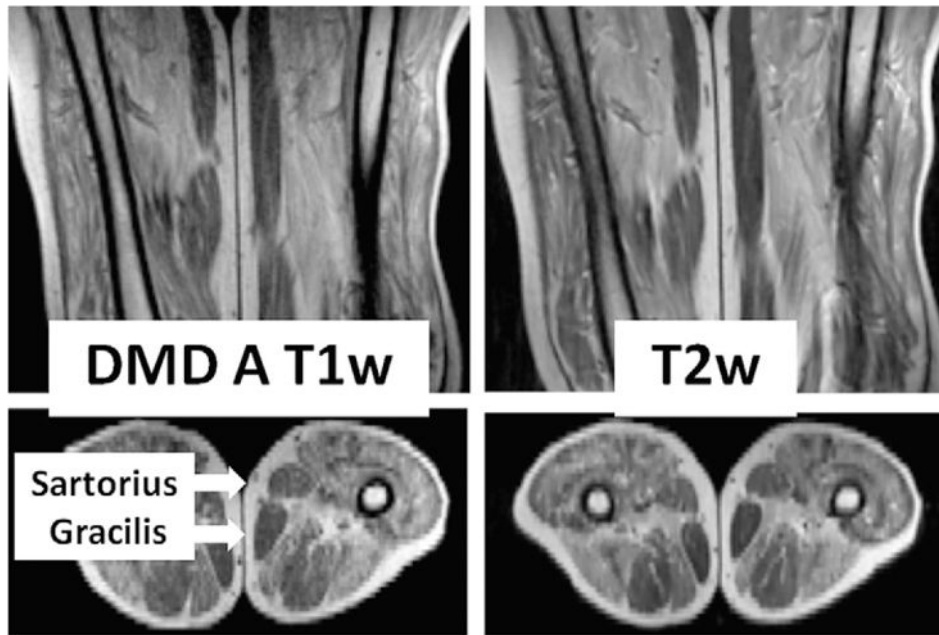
T1- and T2-weighted magnetic resonance images of the proximal leg of a boy with DMD in the anteroposterior (*top*) and transverse (*bottom*) planes. The transverse image is at the level of the midfemur. Most muscles have been partially to near totally replaced with signal-intense material compatible with fat. Note that the subcutaneous fat has comparable signal intensity in both T1- and T2-weighted images. In contrast to the properties of most muscles seen, the sartorius and gracilis muscles (*arrows*) are largely unaffected.
